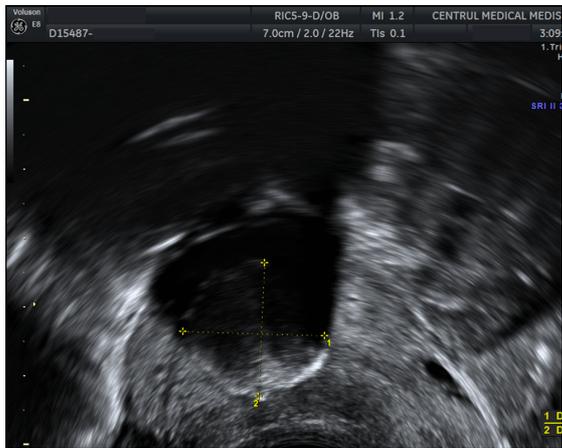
Endovaginal ultrasound-hyperechoic image in the uterine cavity.
